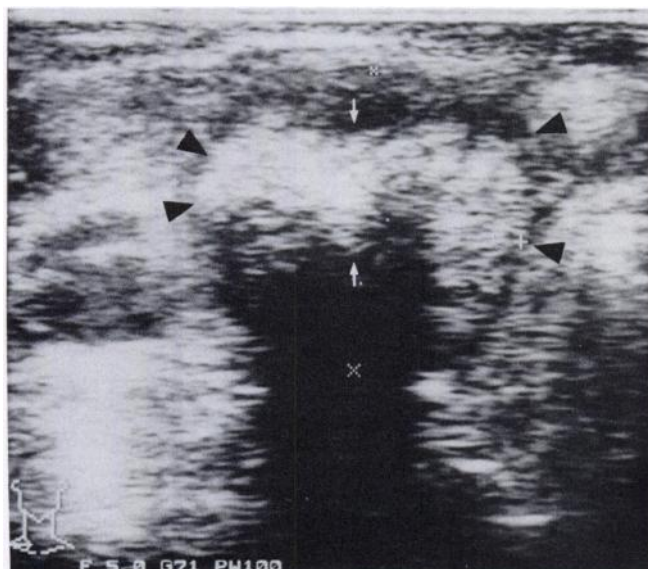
Ultrasound of the right lobe of the thyroid gland. The nodule is well demarcated (black arrows) and contains extensive compact calcifications (white arrows).
